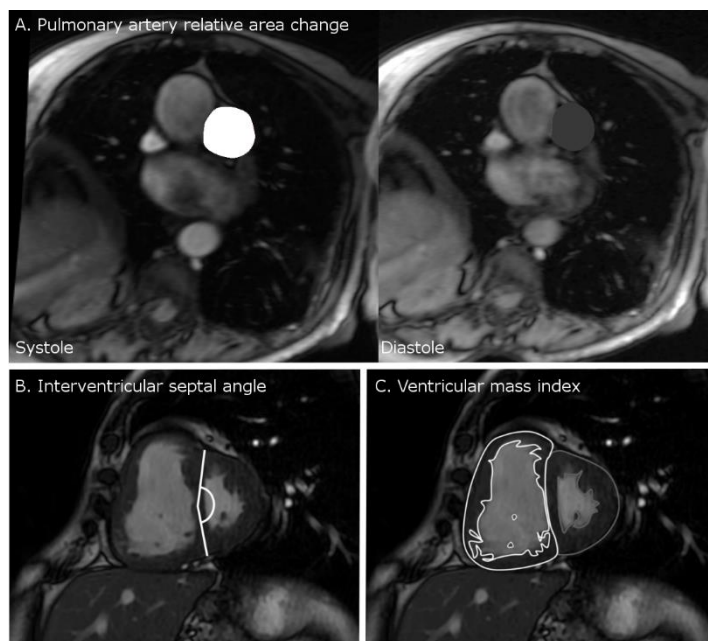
Cardiac MRI metrics. Pulmonary artery relative area change (A) taken from cine images taken at the level of the pulmonary trunk, perpendicular to the main pulmonary artery; septal angle (B) taken as the angle made between the insertion points of the RV to the mid septum on the end-systolic image from the short axis stack; and (C) ventricular mass index taken by segmentation of the muscle mass of the left and right ventricle on the stack of images taken in the short axis plane.
